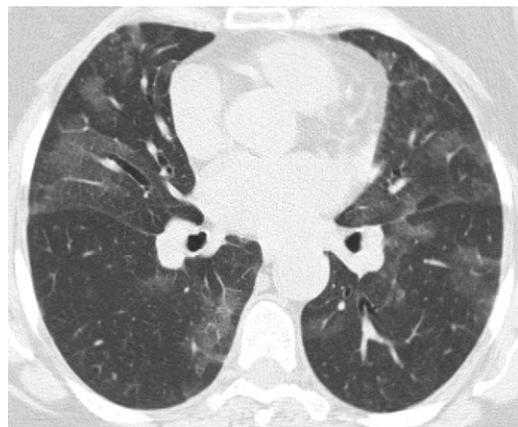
DIP. HRCT of the chest showing more extensive ground-glass opacities in a smoker with DIP.
